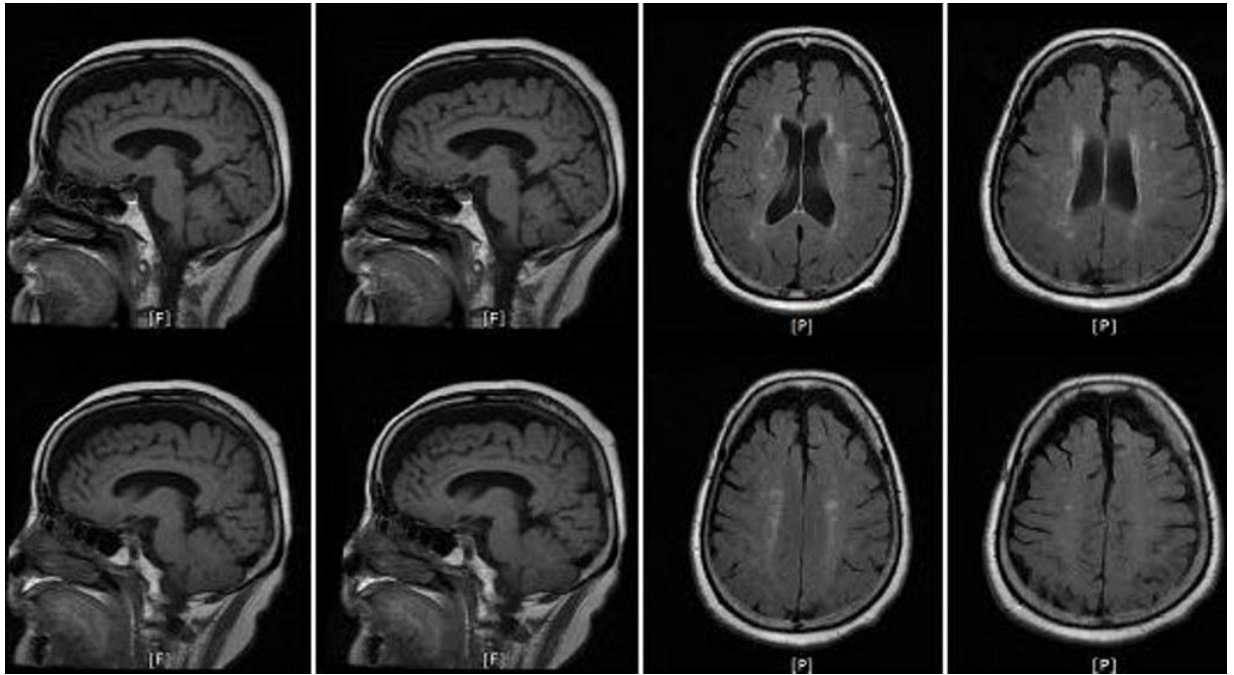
No specific findings other than global brain atrophy on Brain MRI
